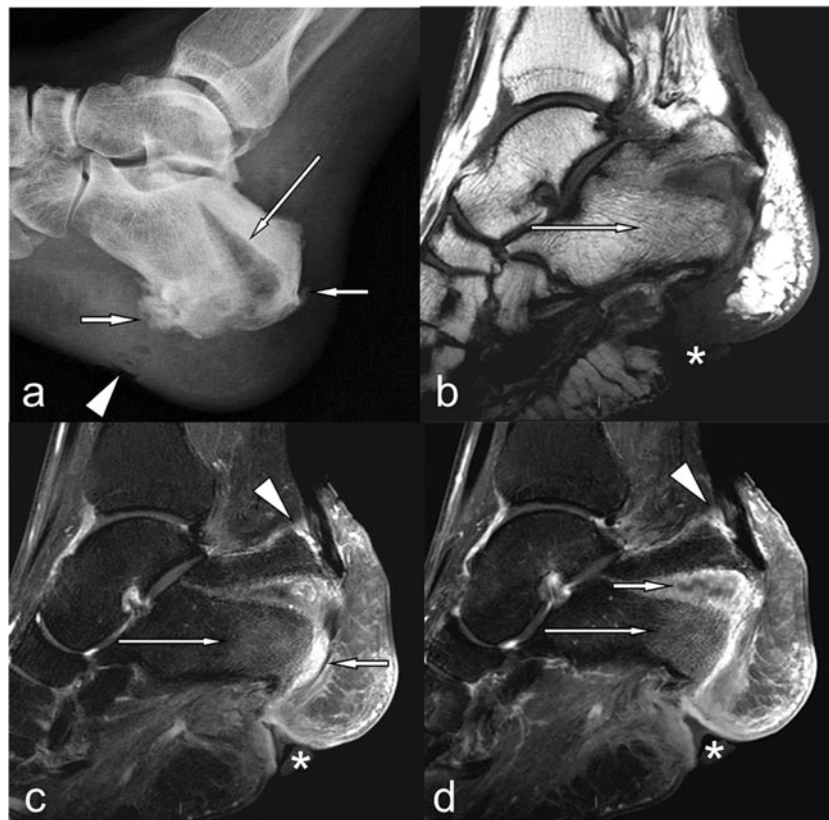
Calcaneal insufficiency avulsion fracture extending to the plantar surface associated with osteomyelitis, heel ulcer, and sinus tract in a 66-year-old woman with an 18-year history of insulin-dependent diabetes. a Lateral radiograph clearly shows the calcaneal avulsion fracture (*arrow*) and the heel ulcer (*arrowhead*). Large calcaneal enthesophytes are also evident (*small arrows*). b Sagittal T1-weighted and c, d post-contrast T1-weighted fat-suppressed MR images show an enhancing deep sinus tract with “tram track” pattern extending down from the calcaneal fracture to
